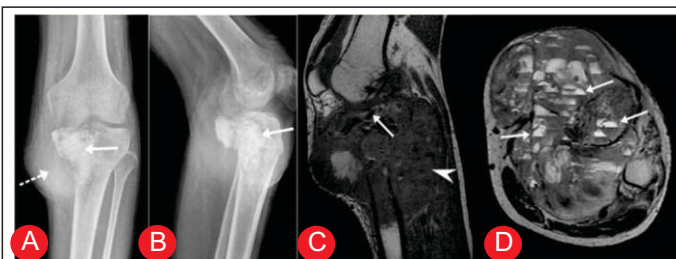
Telangiectatic osteosarcoma. AP (A) and lateral (B) radiographs show a lytic-sclerotic lesion in the (straight arrow) in the upper tibial metaphysis with soft tissue involvement (dotted arrow). (C) T1-weighted sagittal image shows articular cartilage destruction (arrow) and joint involvement. (D) T2-weighted axial MR image shows the expansive mass involving the proximal tibia, extending into the surrounding soft tissue and showing multiple focal cysts like areas with fluid-fluid levels suggestive of intralesional hemorrhage (arrow).
